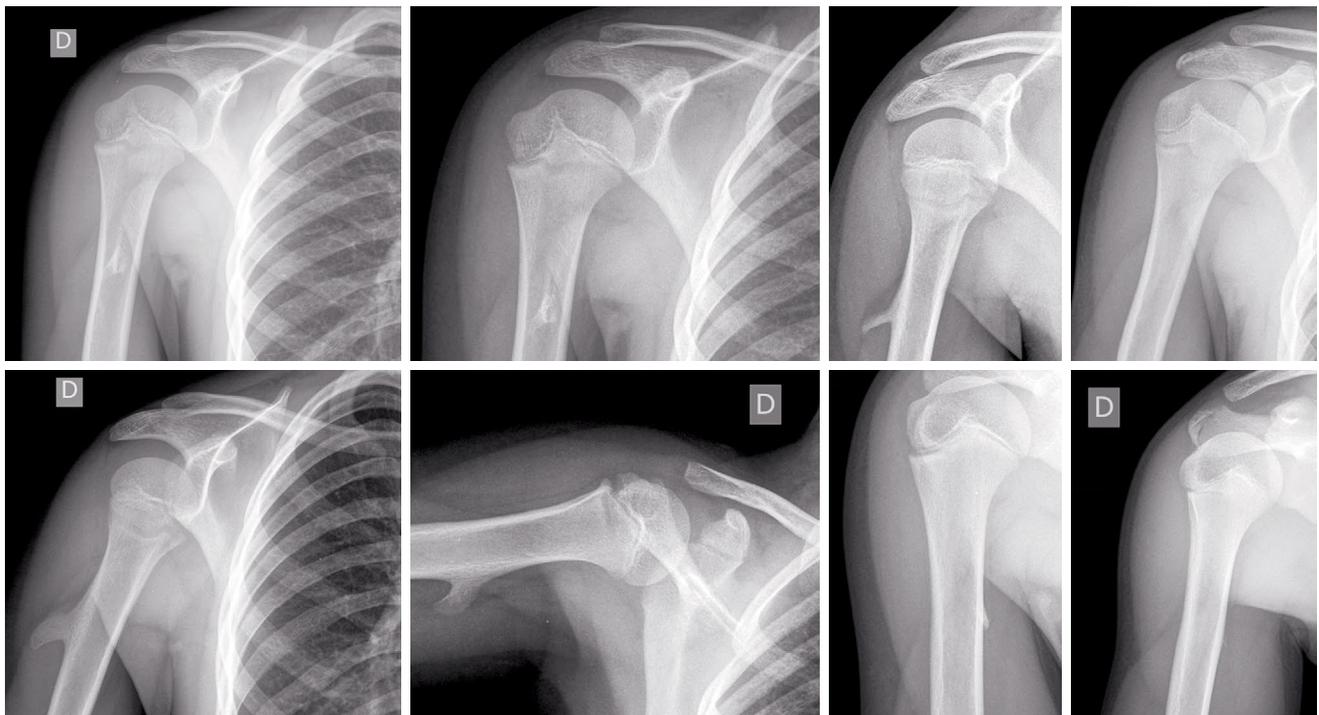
Anteroposterior radiographies of the right shoulder. An 11-year-old boy with an osteochondroma in proximal humerus followed by X-ray for four consecutive years.
